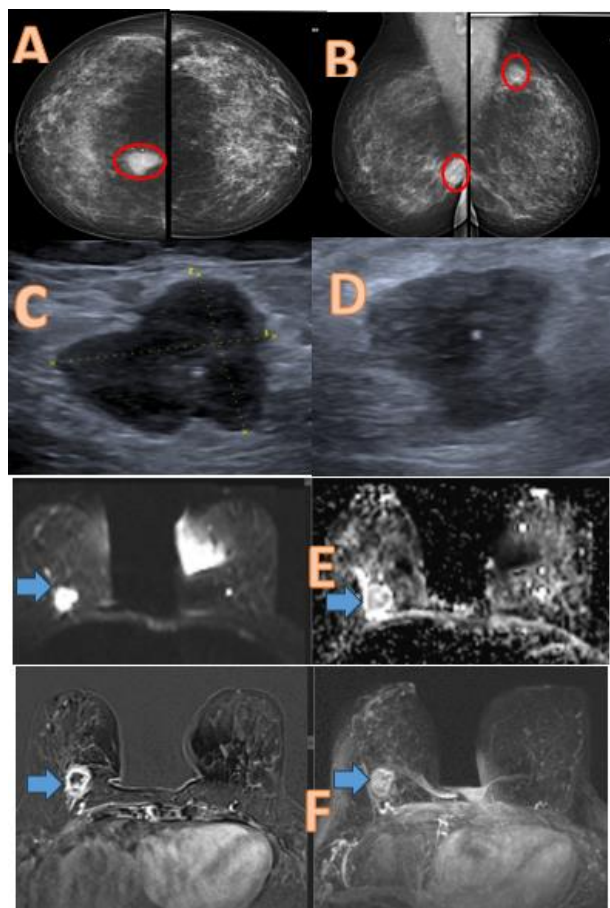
(A) Bilateral mammography CC & (B) MLO showing dense breast (ACR c) with right LIQ irregular indistinct high-density mass with internal microcalcification, left upper quadrant asymmetry. (C) & (D) US show irregular indistinct hypoechoic mass with internal calcification. (E) DWI shows LIQ mass of restricted diffusion (high in DWI, low ADC), (F) MRI-DCE show right LIQ irregular indistinct heterogenous enhancing mass. (blue arrow), no evidence of enhancing mass or restricted masses on the left side.
